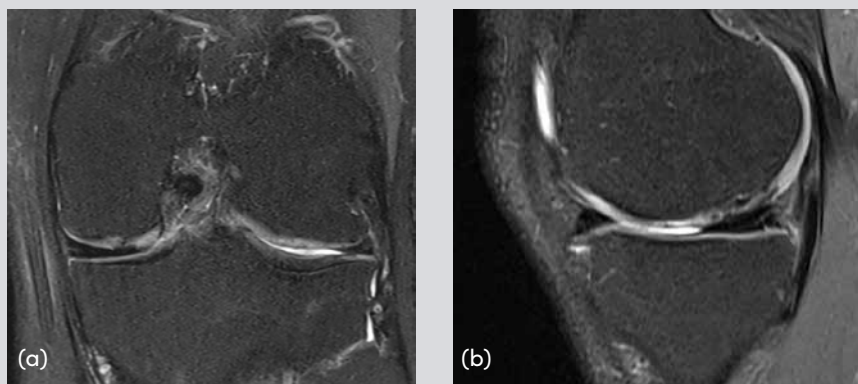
MRI of the left knee two years after surgery following minced cartilage implantation at the medial femoral condyle in the coronal plane (a) and the sagittal plane (b).
